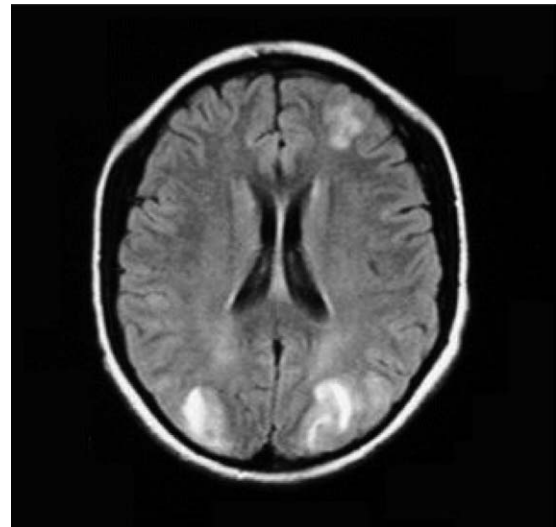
T2-weighted axial MRI. Zones of corticosubcortical hypersignal at occipital and left frontal level.
